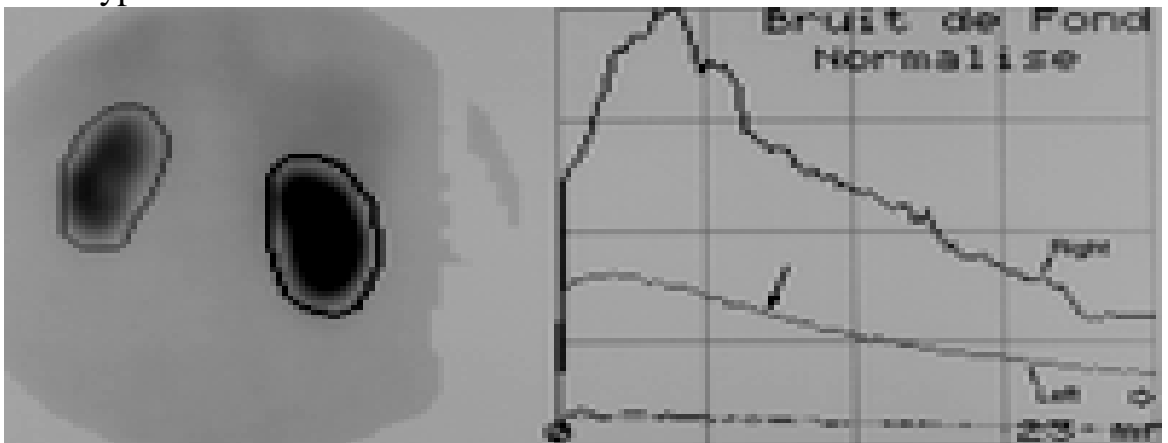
renoscintigraphy kidney
